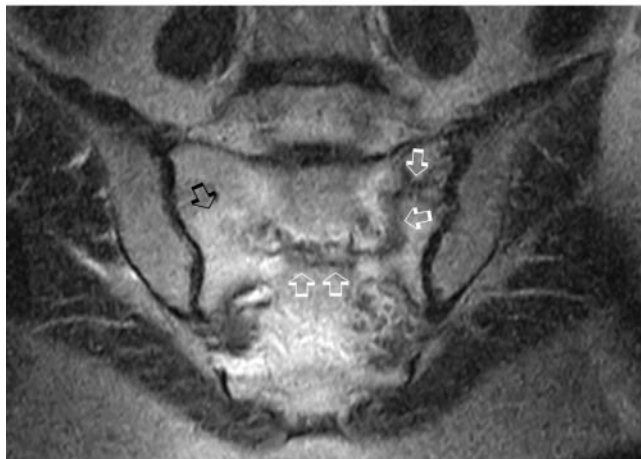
A 76-year-old female with rheumatoid arthritis and new onset of severe low back pain. She also had weight loss, anorexia and possible left iliac fossa mass and malignancy was strongly suspected. (a) Plain radiograph fails to demonstrate significant abnormality. (b) Axial  $T_1$  weighted MR image (repetition time 700/echo time 20) demonstrating low signal intensity in both sacral alae. Because of the suspicion of malignancy, intravenous gadolinium chelate was given. (c) The post-contrast  $T_1$  weighted axial MR image (repetition time 700/echo time 20) shows enhancement through the sacral ala, with linear defects representing fracture lines. (d) Posterior view of isotope bone scan shows an asymmetric H-shaped appearance of bilateral sacral insufficiency fracture, the uptake being more marked in the right sacral ala (arrow). (e) CT scan through the sacrum shows no space-occupying lesion and confirms the bilateral insufficiency fracture (arrows).
